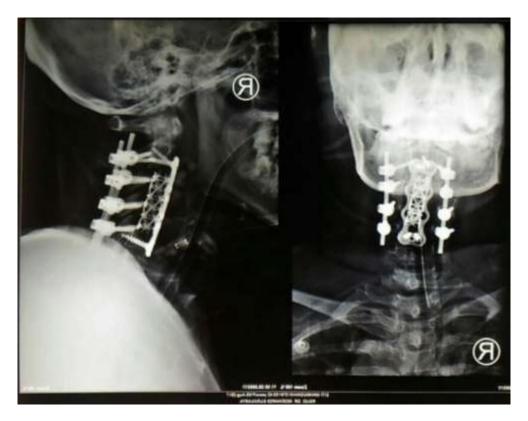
Cervical X-Ray post-Anterior Stabilization with Non-expandable Cage
